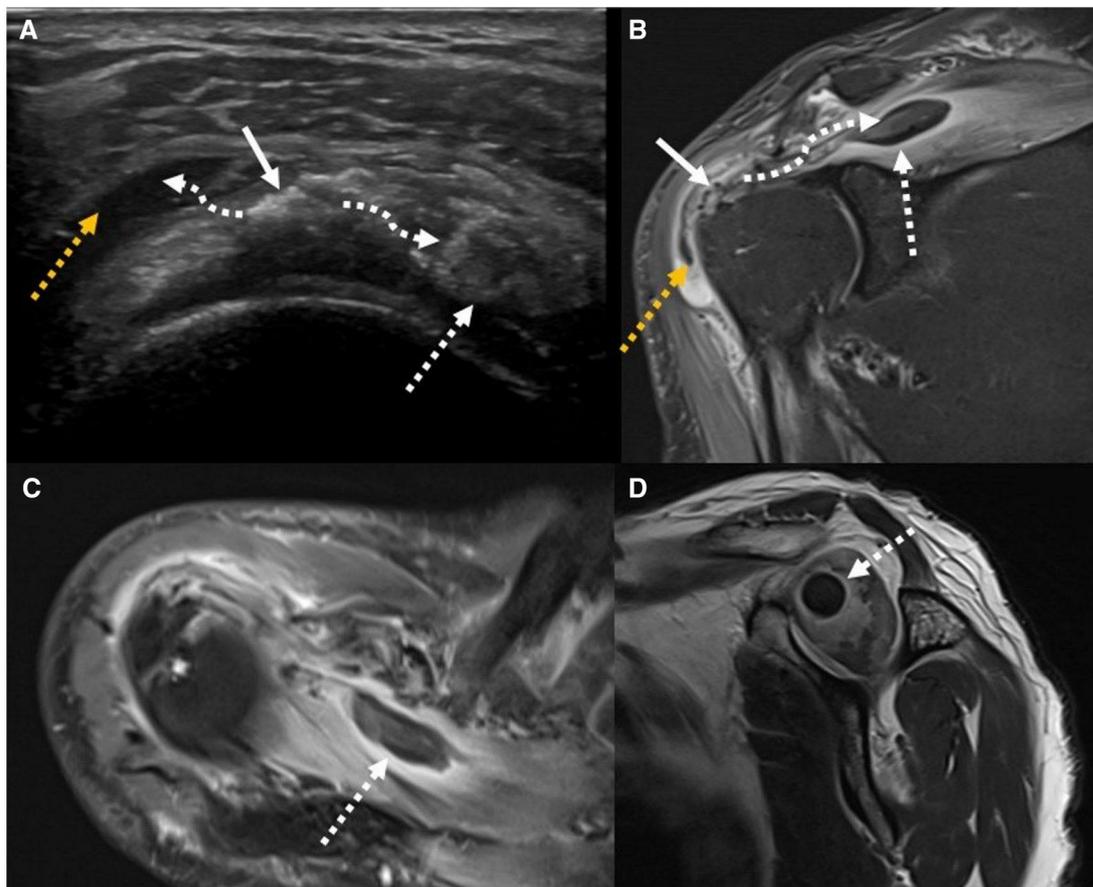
Supraspinatus calcific tendinopathy with intrabursal and intramuscular migration; Ultrasonography (A) showing calcification in the supraspinatus tendon suggesting calcific tendinopathy (white arrow) with migration of calcium (curved dashed arrows) into the bursa (yellow dashed arrow) and muscle (white dashed arrow), MRI T2W fat suppressed coronal (B), fat-suppressed T2W axial (C), and T2W sagittal (D) sequences showing supraspinatus calcific tendinopathy as signal voids (white arrow) with migration of calcium (curved dashed arrow) into the bursa (yellow dashed arrow) and muscle belly (white dashed arrows).
